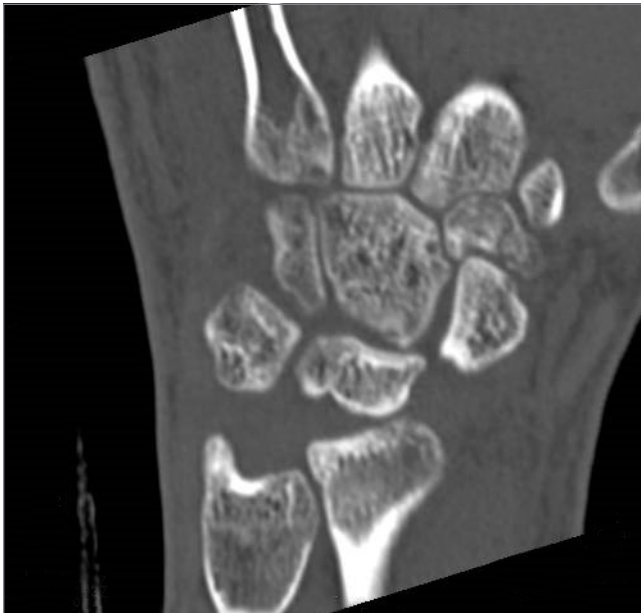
Computed tomography shows trapezoidal fracture.
